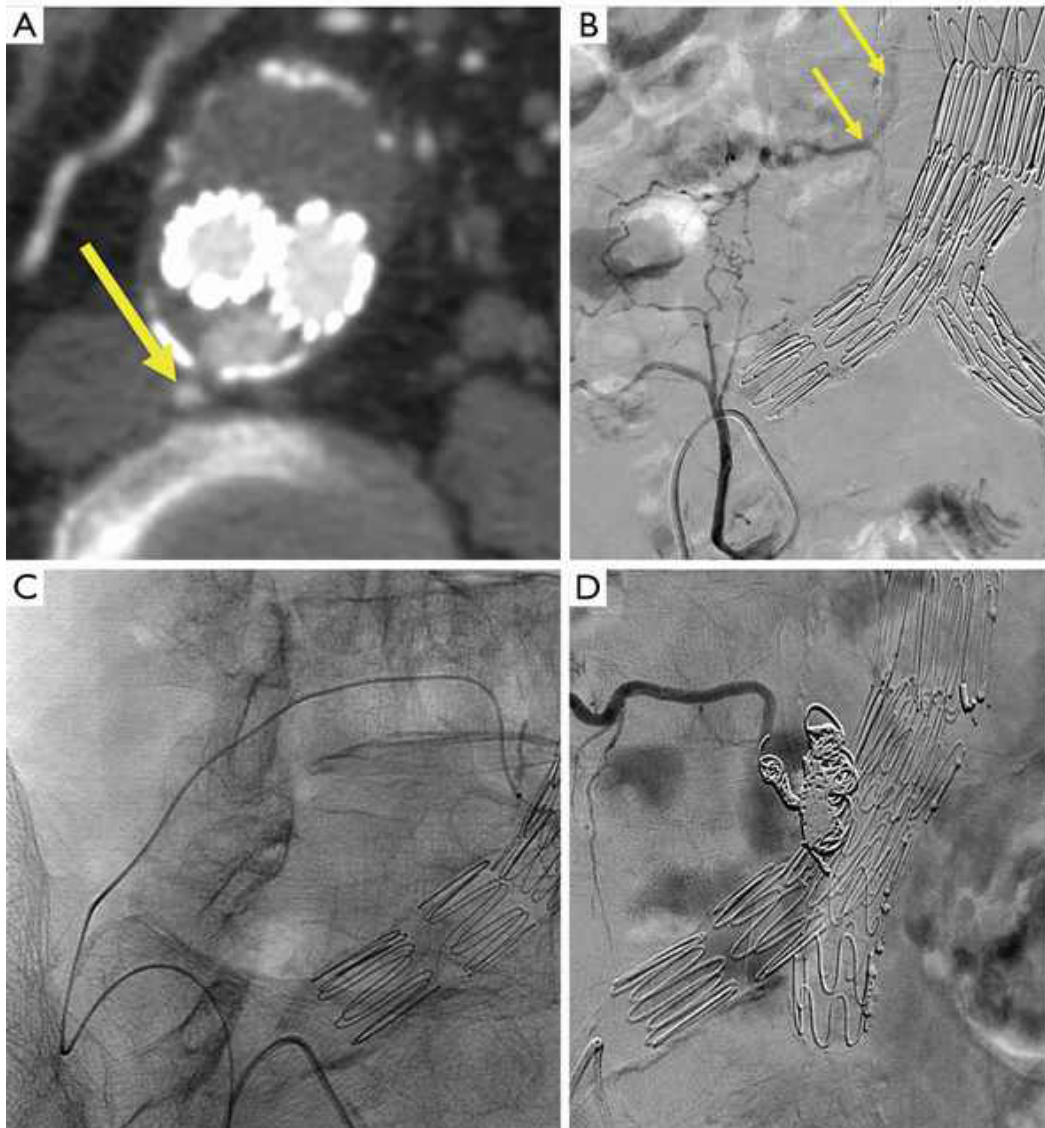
Transarterial coil embolization of a type II endoleak. (A) A type II endoleak fed by a lumbar artery is identified on contrast enhanced computed tomography (CT); the arrow points to the feeding vessel. (B) Selective angiogram of the right internal iliac artery demonstrates that the lumbar vessel (arrows) is fed by the right iliolumbar artery. (C) A microcatheter is advanced to the endoleak. (D) The endoleak nidus and feeding artery have been coiled. There is no opacification of the endoleak upon contrast administration. Adapted from (36).
